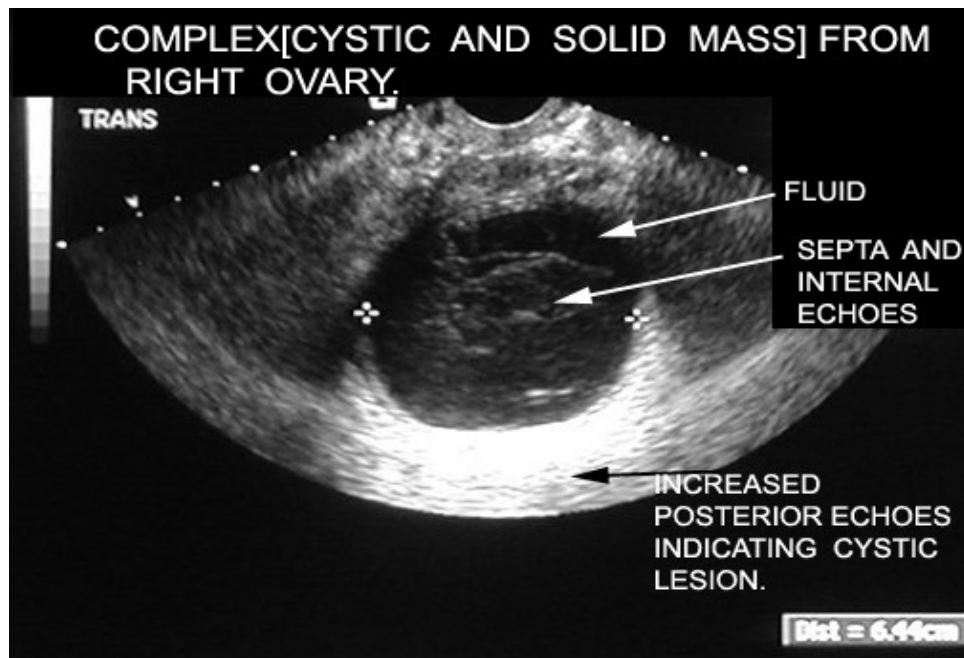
Ovarian Cancer - (www.ultrasoundimagegallery.com)
